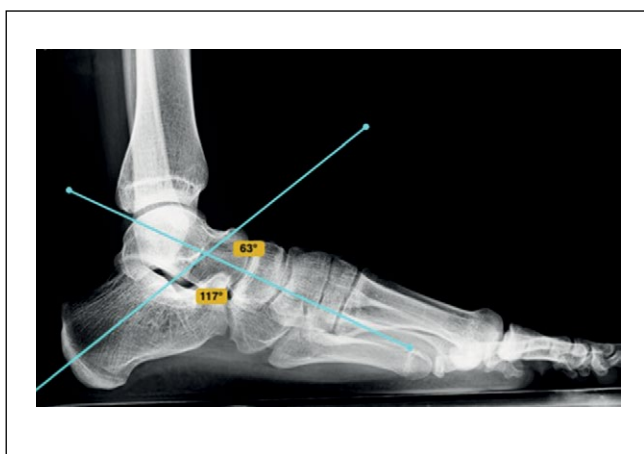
X-ray of the right foot in the lateral projection under load.
